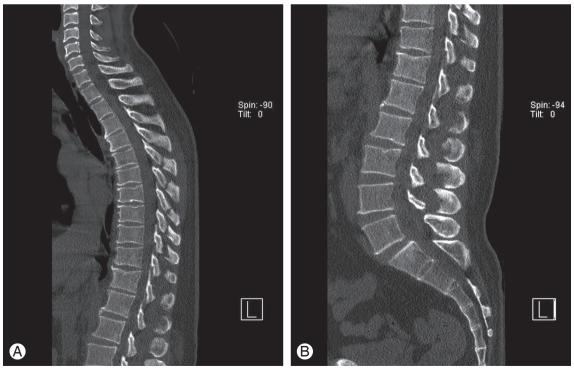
Sagittal view of computed tomography of (A) thoracic spine and (B) lumbar spine. It's found that multiple spinous process fractures, T6-L5, are continued.
